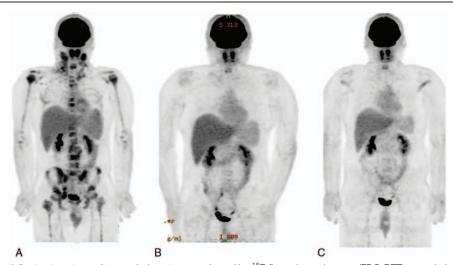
(A) Before imatinib treatment, positron-emission tomography with ¹⁸F-fluorodeoxyglucose (FDG-PET) revealed FDG uptake in multiple lymphadenopathies throughout the body and the red bone marrow. (B) Six months after initiating imatinib therapy, the FDG-PET scan showed no FDG uptake in the lymph nodes or the red bone marrow. (C) One year after initiating imatinib therapy, the FDG-PET scan also showed no FDG uptake in the lymph nodes or the red bone marrow.
